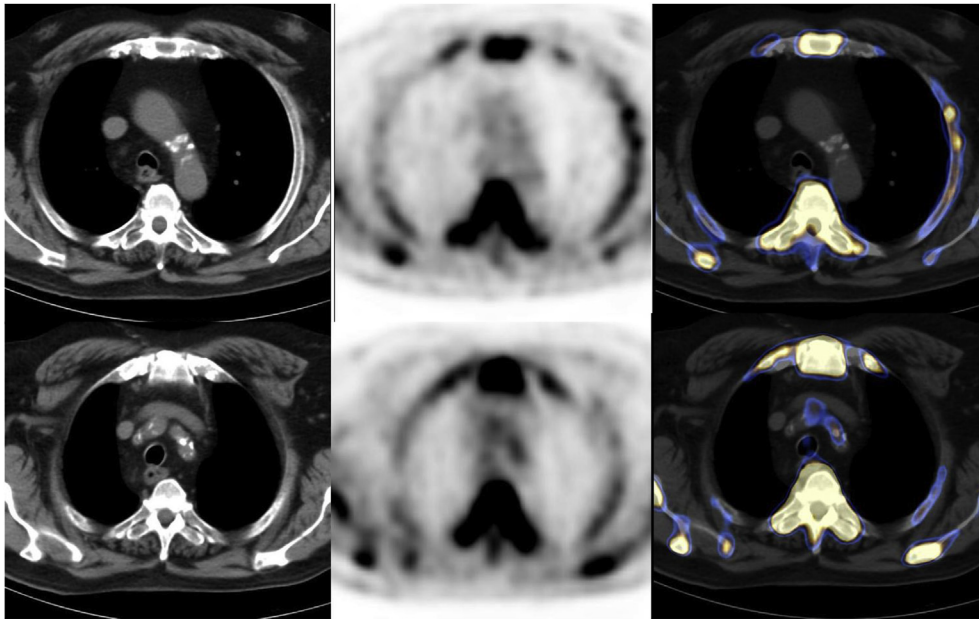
Fusion ^{18}F -NaF-PET-CT images, depicting calcified plaques with no uptake (top) and with ^{18}F -NaF uptake (bottom).
